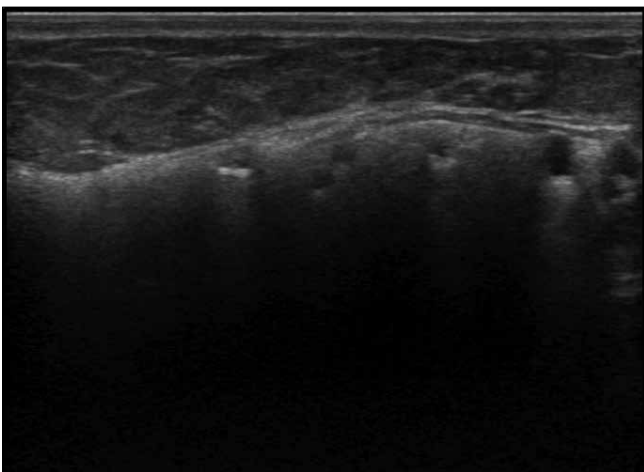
Ultrasound image shows multiple globules of silicone appearing as small anechoic cystic lesions that have ill-defined borders and posterior acoustic shadowing; so-called 'snowstorm' pattern
